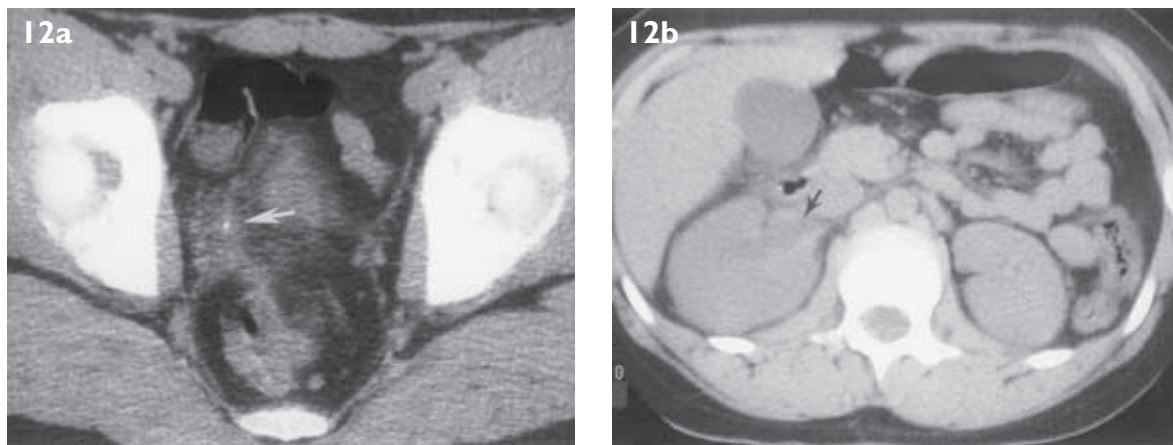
Ureteral calculus. A) CT shows a calculus in the distal right ureter (arrow). The ureteral wall appears swollen. B) A CT image at the level of the kidneys shows increased size, decreased attenuation and slight collecting system fullness (arrow) of the right kidney, indicative of obstruction. Slight edema is noted in fat adjacent to the renal hilus and margins of the right kidney are slightly indistinct.
